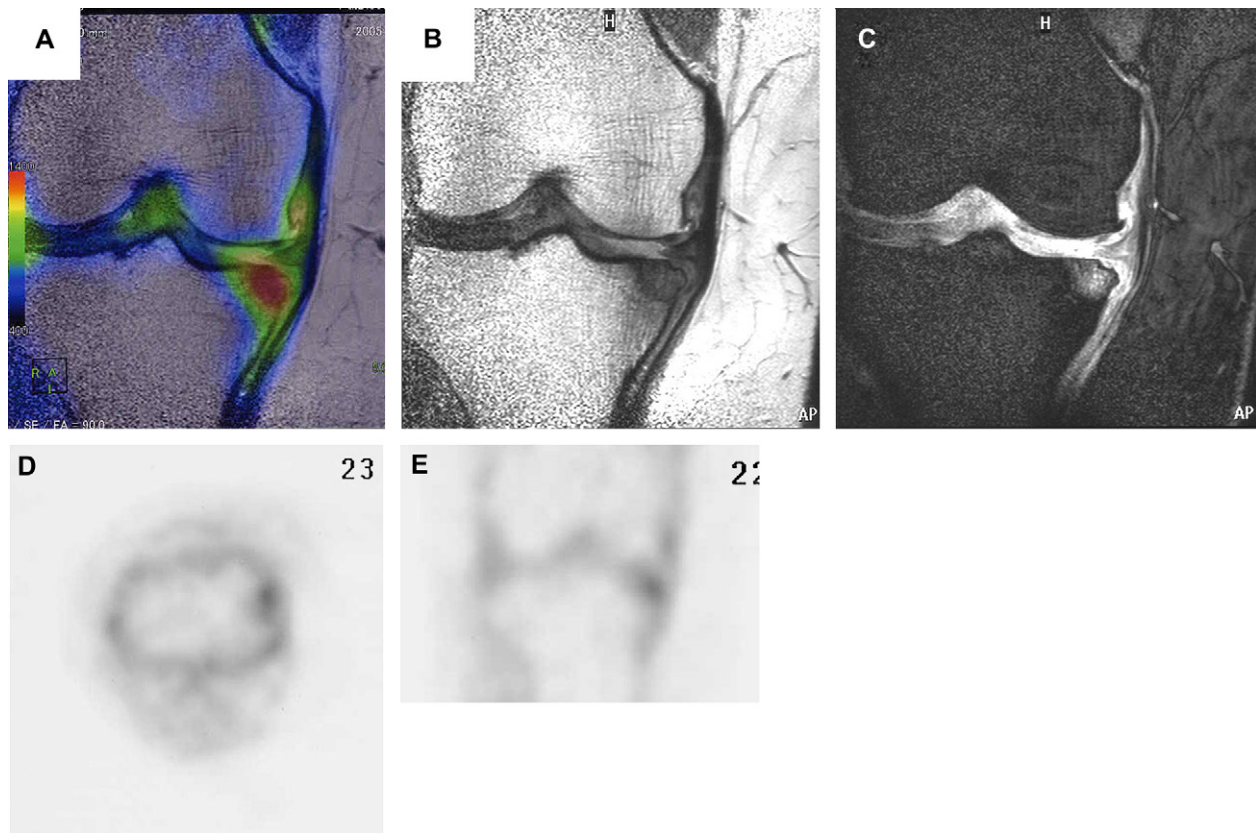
$^{18}\text{F}$ -FDG accumulated in the subchondral lesion of the base of the osteophytes. MRI study suggested the lesion as bone edema. (A) Fusion image, (B) proton density-weighted MRI, (C) fat-suppressed MRI, (D) PET axial view, and (E) PET coronal view.
